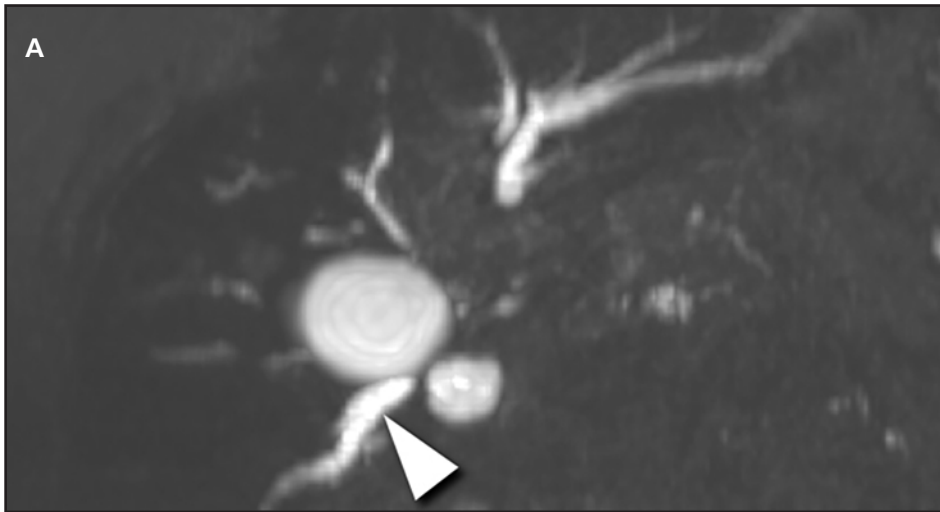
Biliary obstruction in a 69-year-old woman with cholangiocarcinoma. T2-weighted MRI of the abdomen in the coronal plane demonstrates a large mass (arrow) at the neck of the dilated gallbladder obstructing the intrahepatic biliary ducts at the hilum. The distal CBD (arrowhead) is unobstructed.
